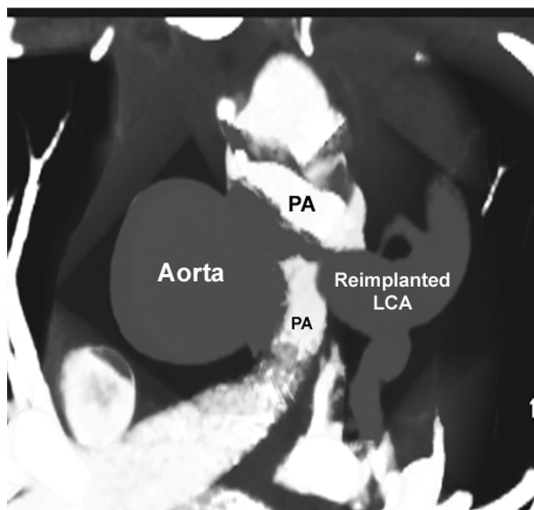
CT angiography image showing a reimplantation of the LCA to the aorta.
